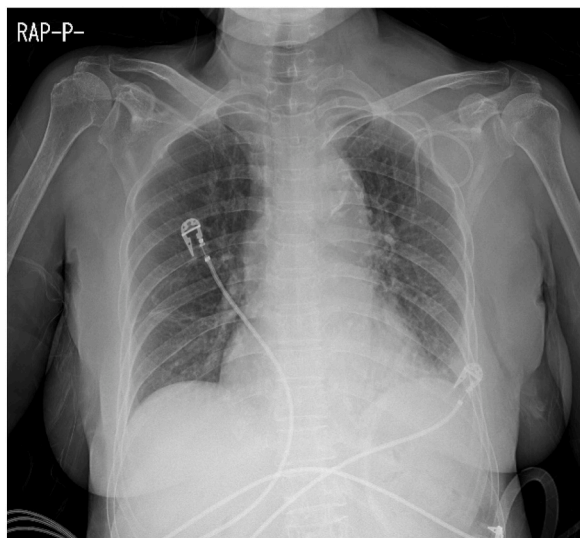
Chest X-ray on POD6.
